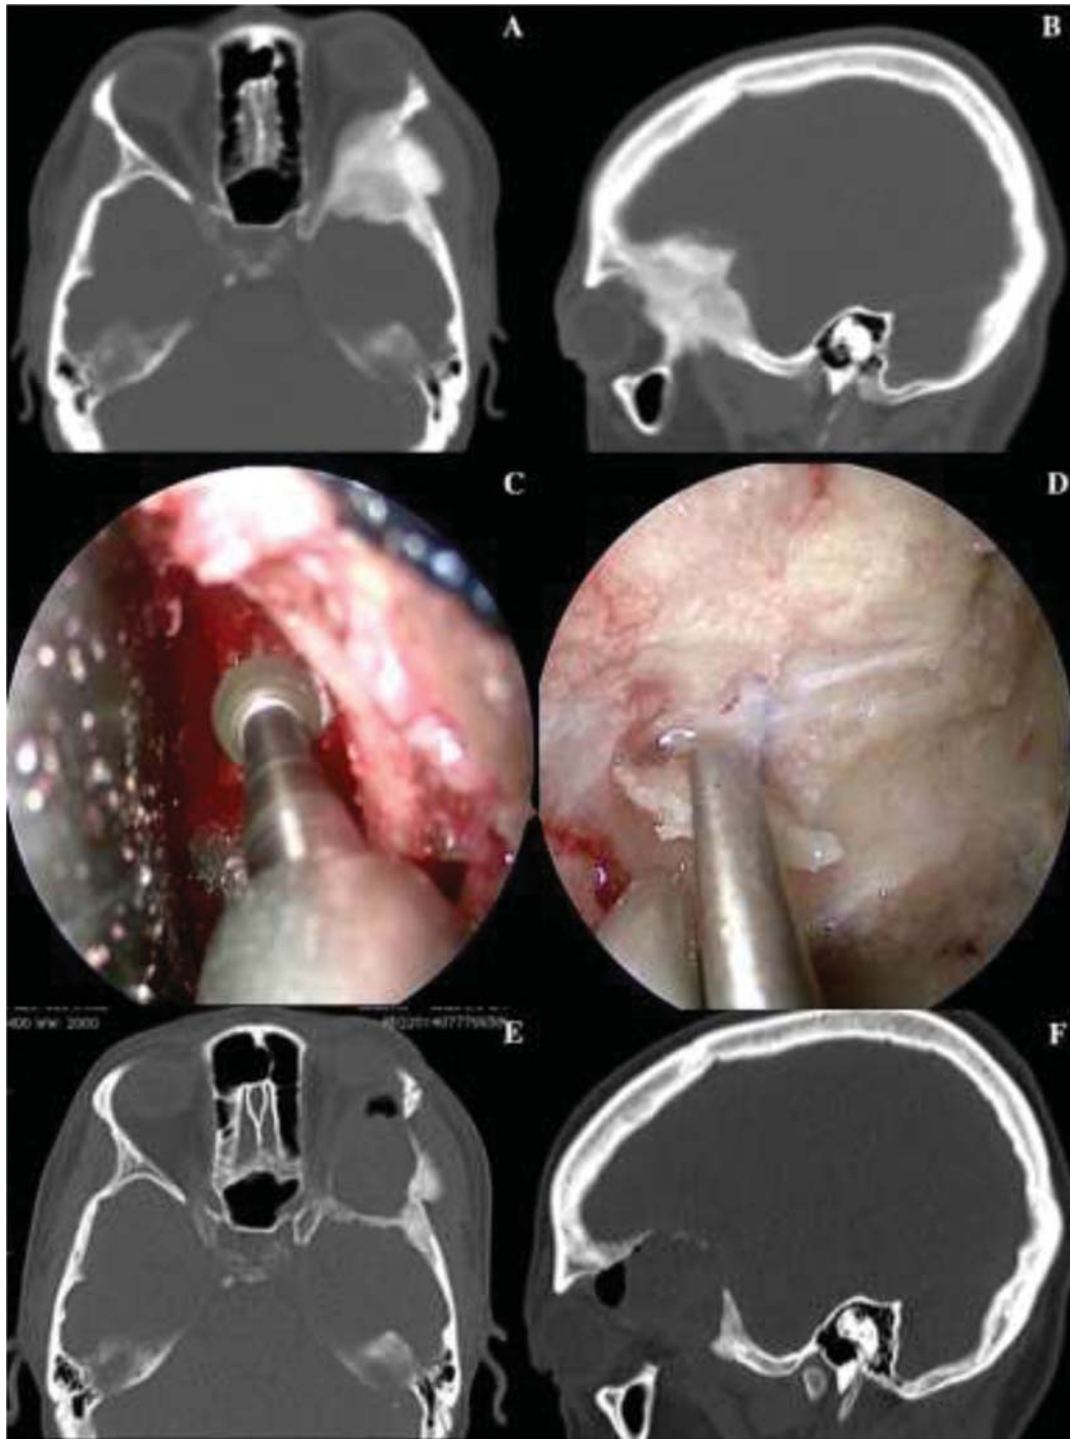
Endoscopic superior eyelid approach to a left sphenoidal meningioma. (A, B) Axial and Sagittal CT scans demonstrating hyperostotic growth. (C, D) Trans-superior eyelid endoscopic views of drilling and resection of the meningioma. (E, F) Postoperative axial and sagittal CT scans.
